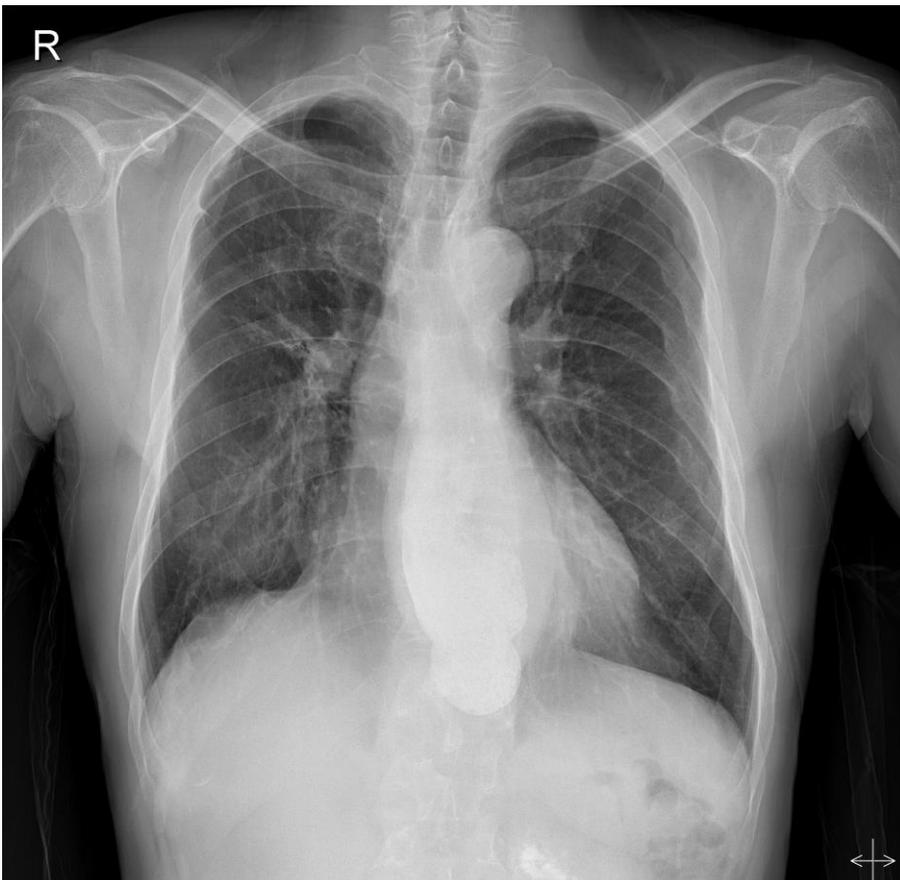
Delayed chest x-ray (ten minutes after videofluoroscopic study) showed that most of the barium was remained of the lower esophagus and was suggested of functional gastric outlet obstruction.
